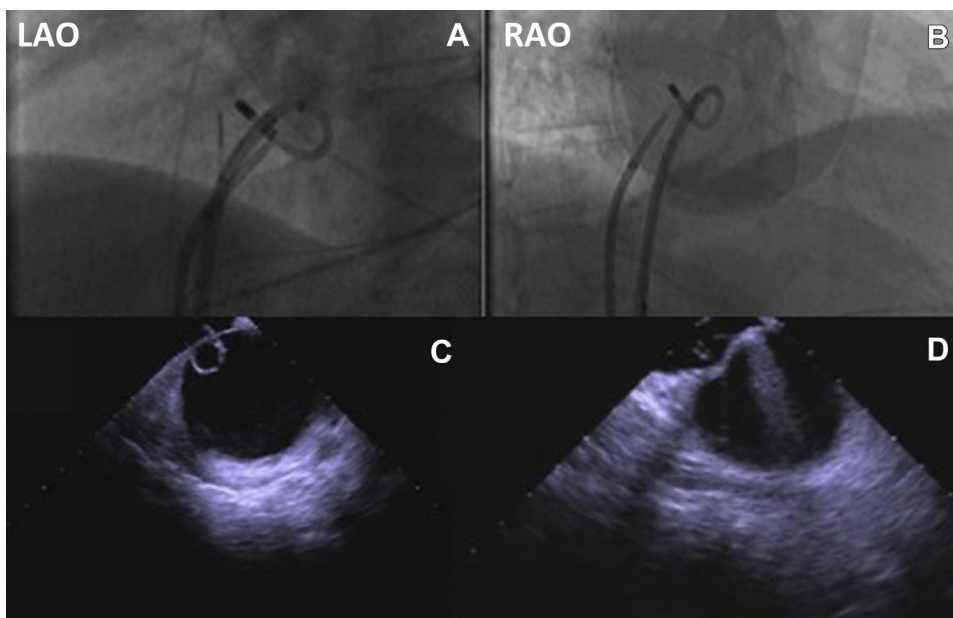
Left anterior oblique (LAO) (A) and right anterior oblique (RAO) (B) fluoroscopic images with curled ablation catheter backward traction being applied on the left atrial side of the interatrial septum, thereby enabling an SL-1 introducer and sheath to reach the interatrial septum. Intracardiac echocardiographic images showing the ablation catheter tightly curved in the left atrium and pulled back onto the left side of the interatrial septum (C), and a more posterior view of the septum showing reverse tenting of the superior portion of the interatrial septum from backward traction on the curved ablation catheter, while the SL-1 dilator is seen tenting the septum toward the left atrium in a more caudal and posterior location than the first transseptal site (D).
